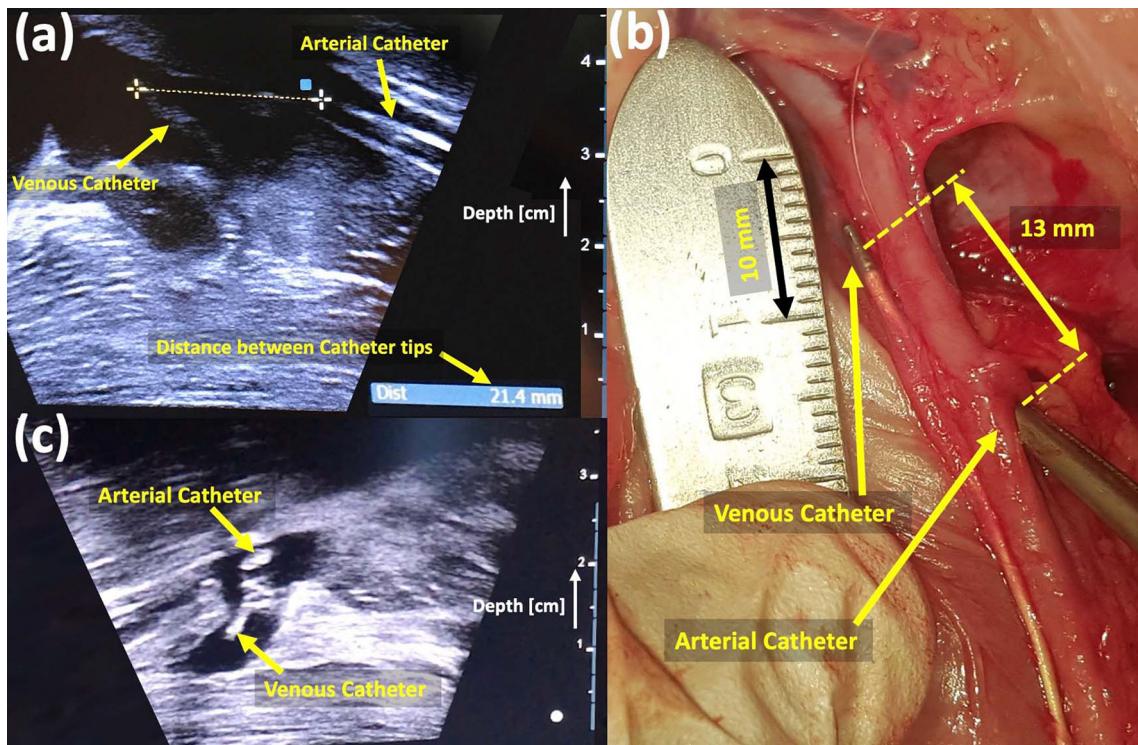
Indications of Millar pressure catheter tip distance proximity: (a) The axial distance was targeted at less than 4cm, which was confirmed during the experiments by ultrasound examination before measurements as well as (b) during post-op dissection. (c) The radial proximity near the tip of the catheters was also confirmed during the experiments with ultrasound before measurements.
